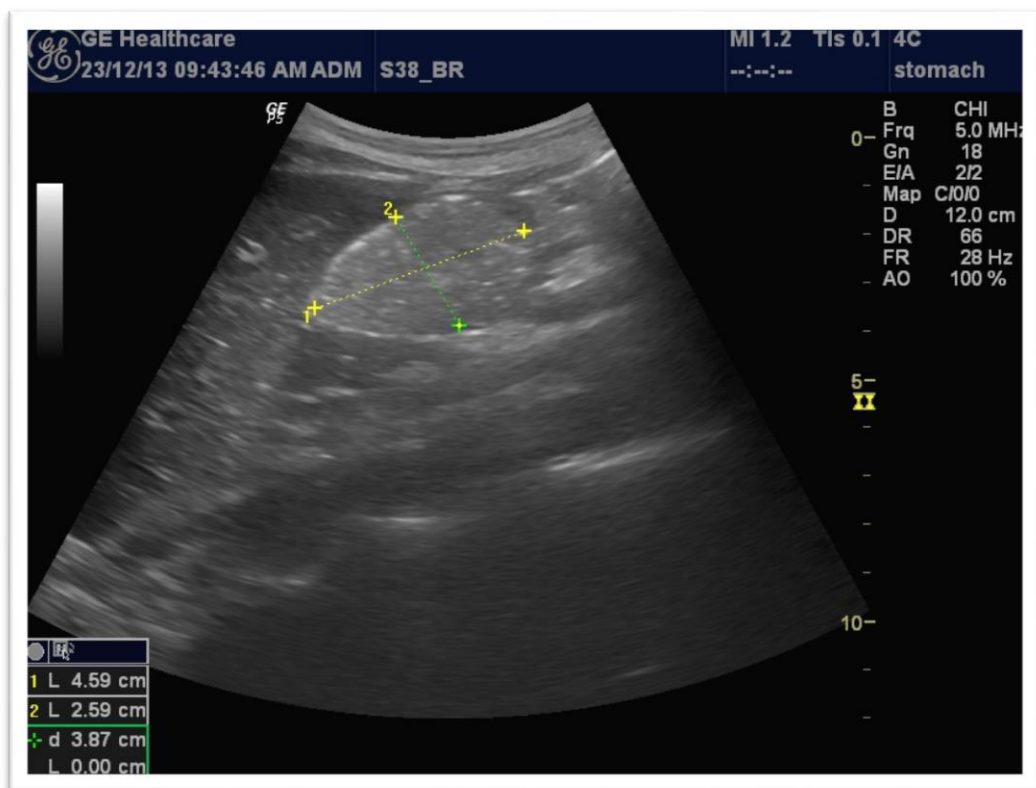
2 Ultrasound photo of the gastric antrum 15 min after rice consumption
